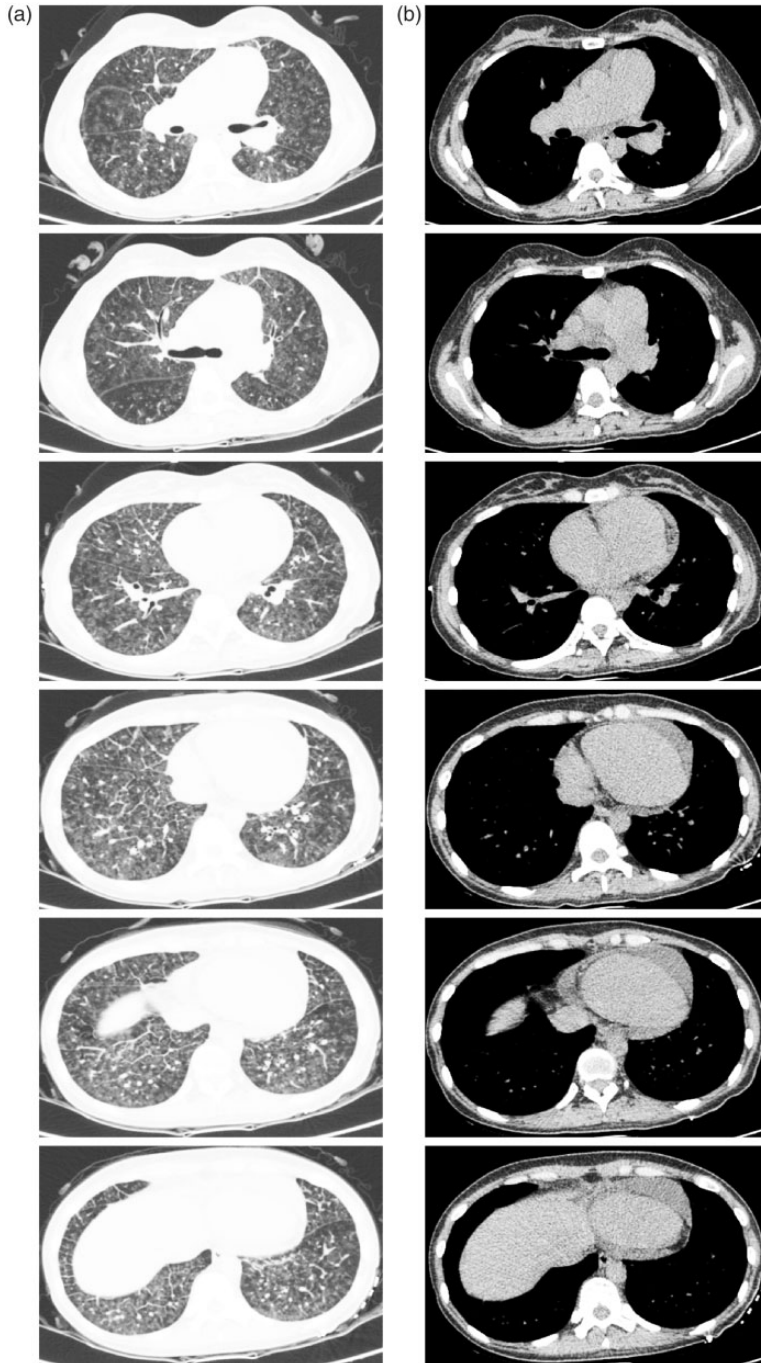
Imaging findings. (a) A chest computed tomography scan revealed diffuse ground-glass opacities in both lungs with thickened septa of both lower lobes, a ratio of the transverse diameter of the main pulmonary trunk to the ascending aorta of >1 , and enlargement of the right ventricle and right atrium. (b) Mediastinal window of (a).
